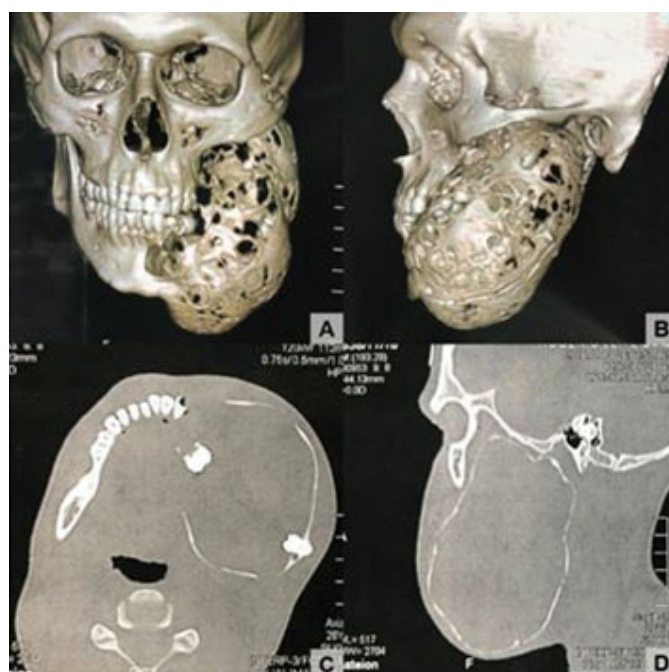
Computed tomography. 3D reconstruction in (A) frontal view and in (B) left lateral view, with an image suggestive of multilocular tumor lesion in the left hemimandible. (C) Axial section with an image suggestive of tumor lesion associated with embedded teeth. (D) Sagittal section with an image suggestive of tumor lesion, with integrity of the adjacent bone structures.
